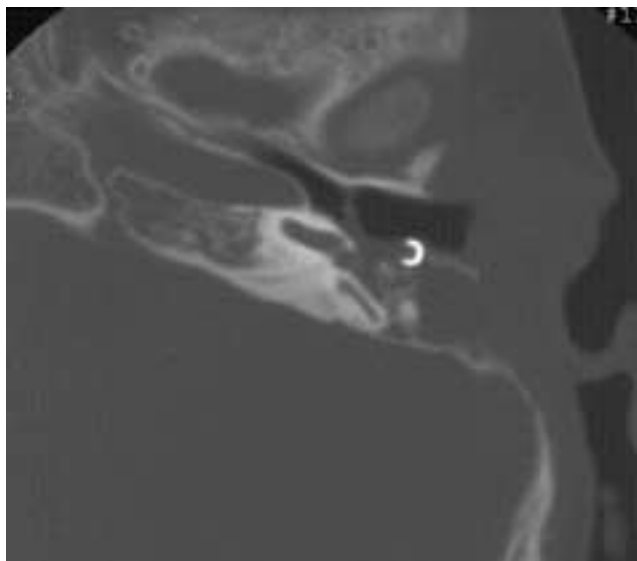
Dislocated Black prosthesis. CT shows dislocation of the egg-shaped hydroxyapatite head of the prosthesis into the external auditory canal.
